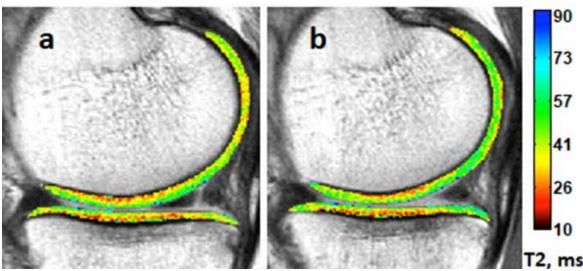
Texture analysis permits quantitation of early changes of T2 distribution in knee articular cartilage following anterior cruciate ligament (ACL) reconstruction. Sample T2 maps acquired prior to (a) and 6 months after (b) ACL reconstruction surgery demonstrate subtle changes to the spatial distribution of T2 values over time while mean T2 values remain stable. Texture analysis permits quantitation of these early changes. T2 maps generated with MRImapper® software (Beth Israel Deaconess and MIT 2006). Figure courtesy of Dr. Constance R. Chu and Ashley Williams. For more information on this work, please see: Williams, et al. Early articular cartilage MRI T2 changes after anterior cruciate ligament reconstruction correlate with later changes in T2 and cartilage thickness. J Orthop Res. 2017 Mar;35(3):699-706.
